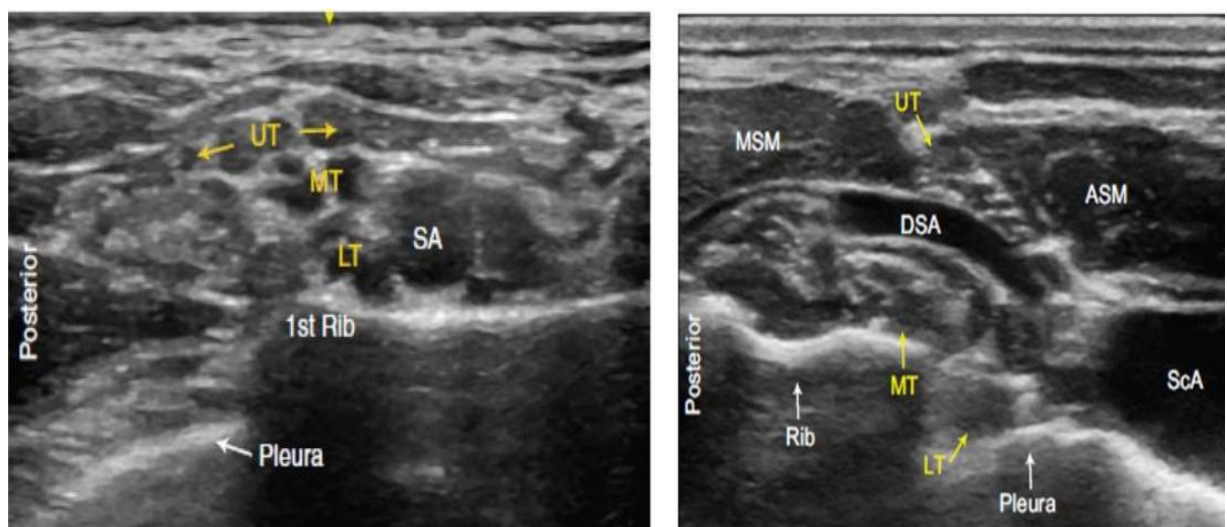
Ultrasound images of the brachial plexus
